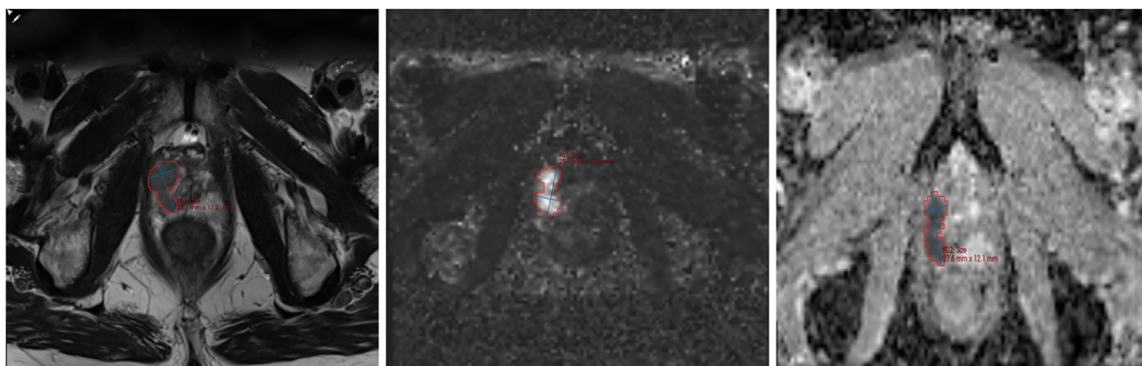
Images showing the measurement of MRI tumor volume using Mint™ software on T2, DWI and ADC map.
